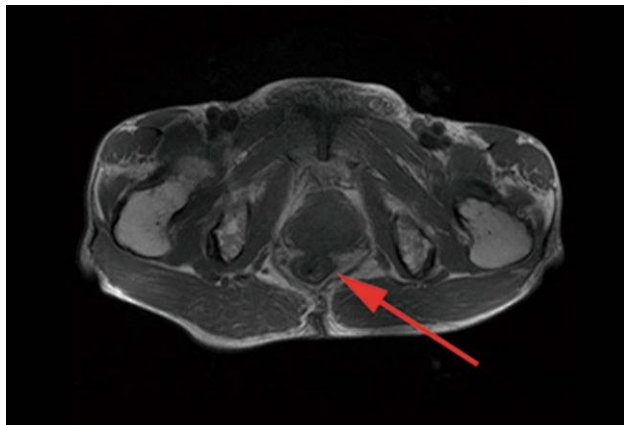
Rectal tumor hinted by enhanced MRI
